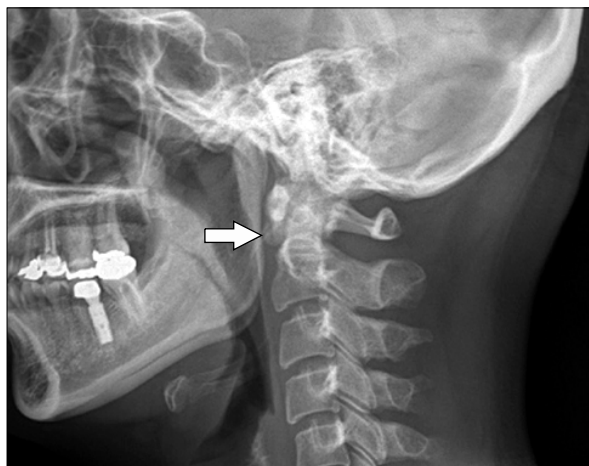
Lateral view plain radiograph of cervical spine shows elongated styloid process at left side (white arrow).
